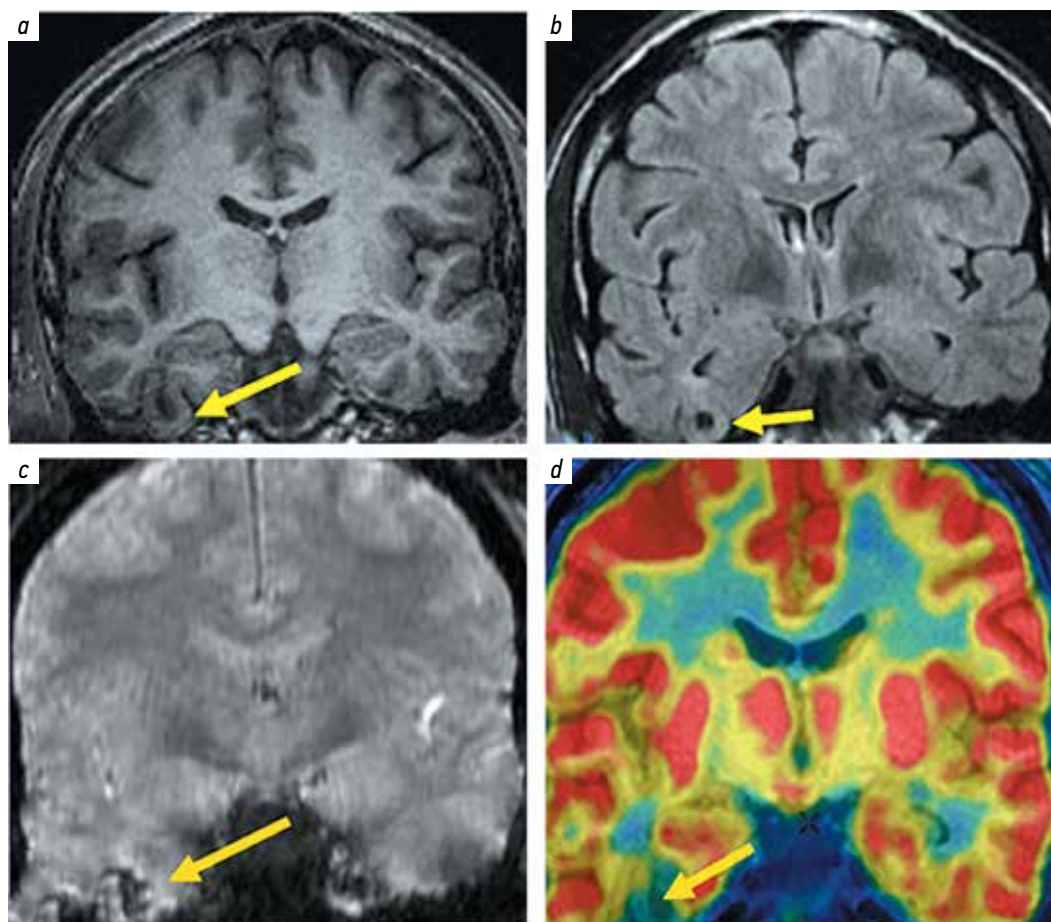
Examination of patient K.: a–c – contrast-enhanced brain magnetic resonance imaging of patient A. according to the epilepsy protocol, T1-weighted (a), T2-weighted (b) and SWAN (c). Cavernoma of the right lateral fusiform gyrus with gliosis and accumulation of hemosiderin on the periphery (yellow arrows); d – positron emission tomography/magnetic resonance imaging of the brain. An area of decreased (up to 40 %) accumulation of radiopharmaceutical drug by the brain matter neighboring the above-described lesions (right temporal lobe) (yellow arrow)
